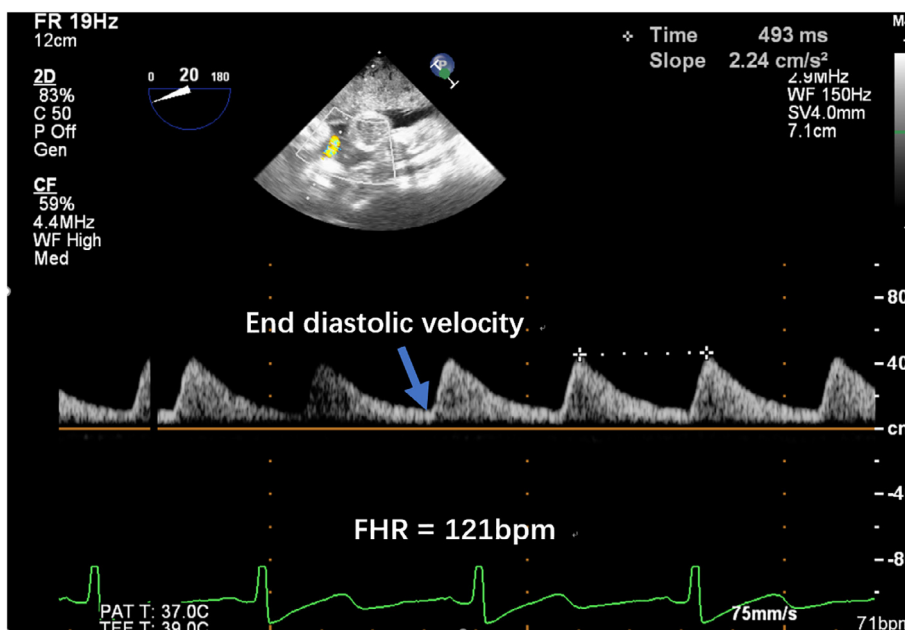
Positive end diastolic volume was present in umbilical artery Doppler studies, fetal heart rate (FHR) was calculated
